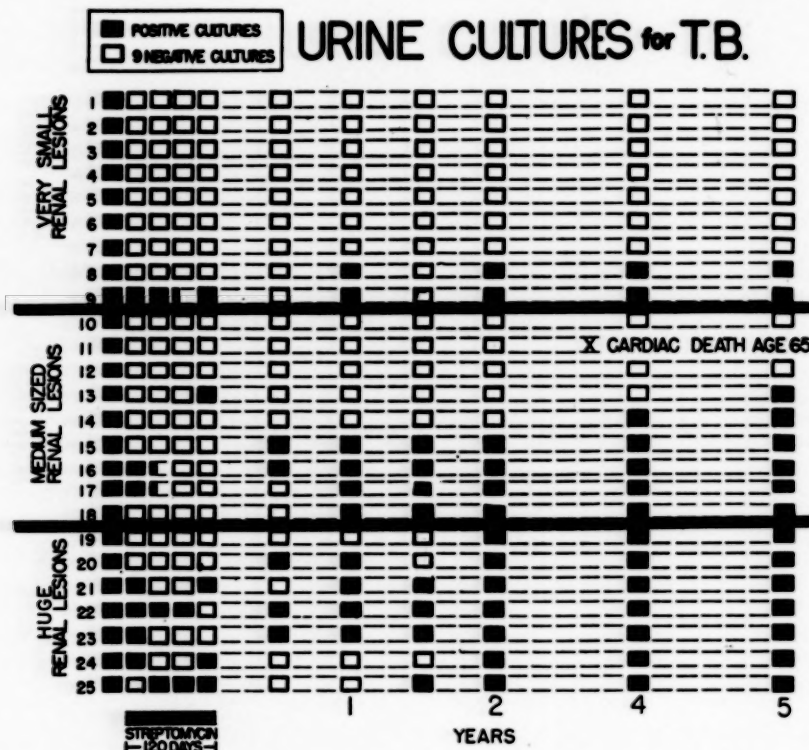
Five-year follow-up after streptomycin therapy, 2 gm. daily for 120 days. Small lesions, not visible by x-ray (top), showed 80 per cent five-year conversions. Patient No. 13 went five years before relapsing.
